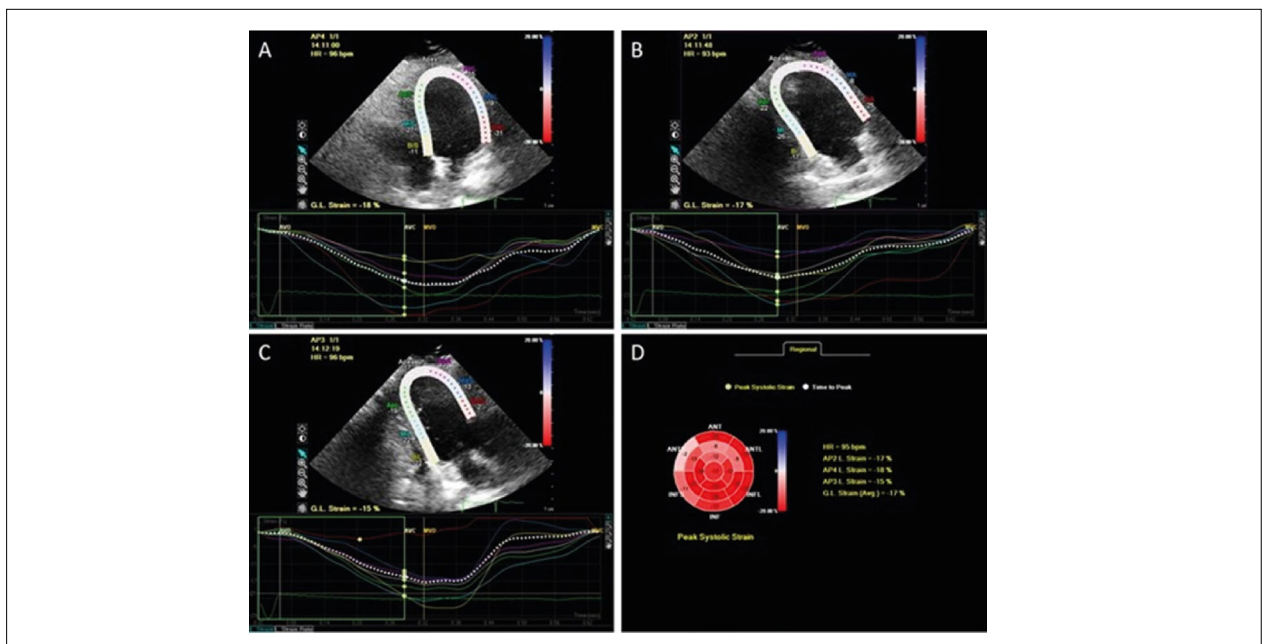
Left ventricular (LV) longitudinal strain analysis in apical four- (A), two- (B), and three-chamber (C) views, and LV global longitudinal strain (D) of a patient with Duchenne muscular dystrophy with a normal LV ejection fraction and a reduced global longitudinal strain (-17%).
